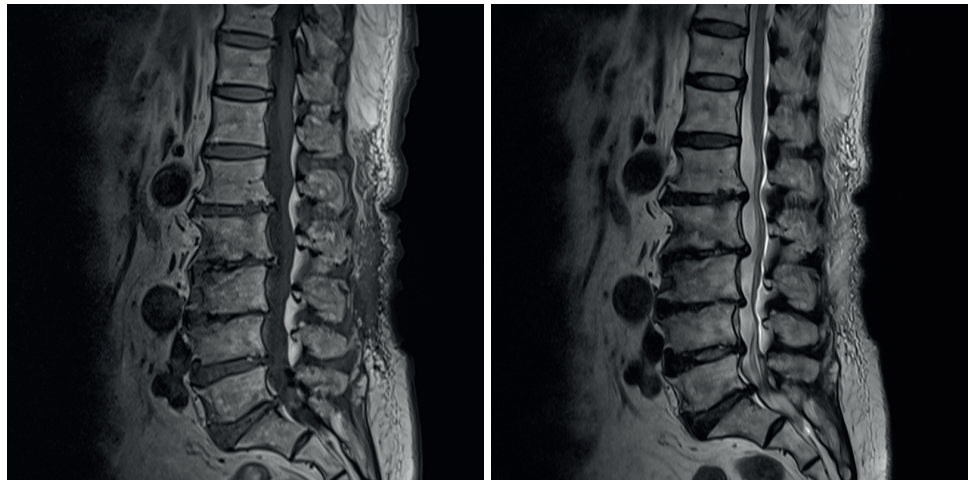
Pre-operative thoracolumbar magnetic resonance images revealed multiple spinal stenosis and degenerative disc changes such as intervertebral disc herniation with narrowing of the disc space.
